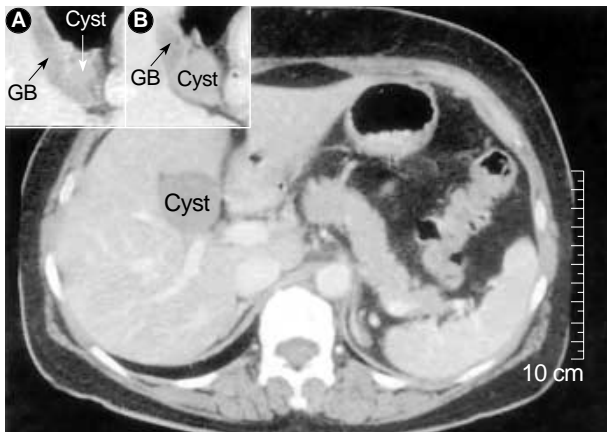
Post-contrast sequential axial abdominal CT scan shows a well-defined round cystic mass at the inferomedial aspect of the gallbladder. The internal density of the cystic mass appears as a subtle increase than that of the gallbladder.
